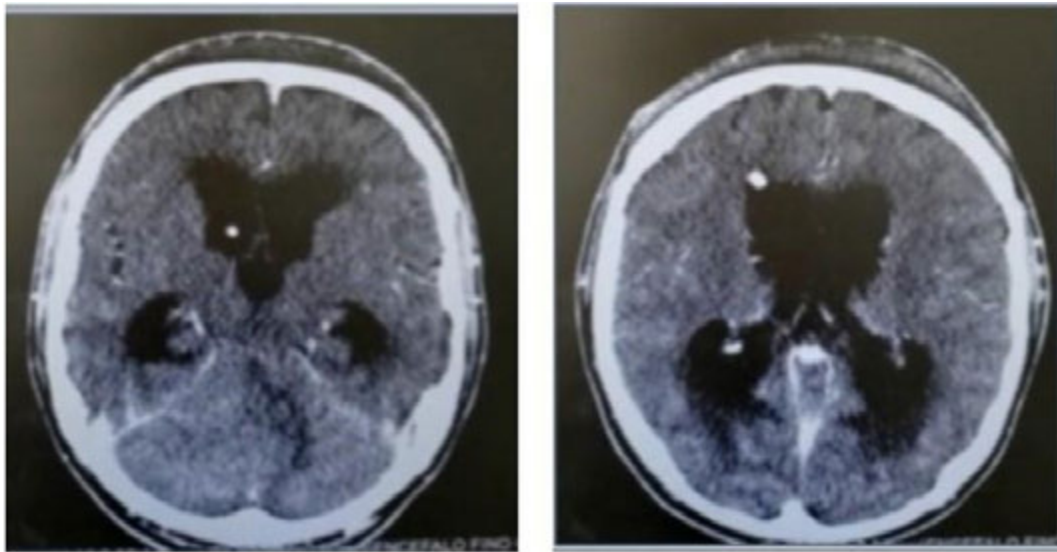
CT (computerized tomography). Infratentorial mass effect and cerebrospinal fluid transudation. External ventricular shunt conduct.
